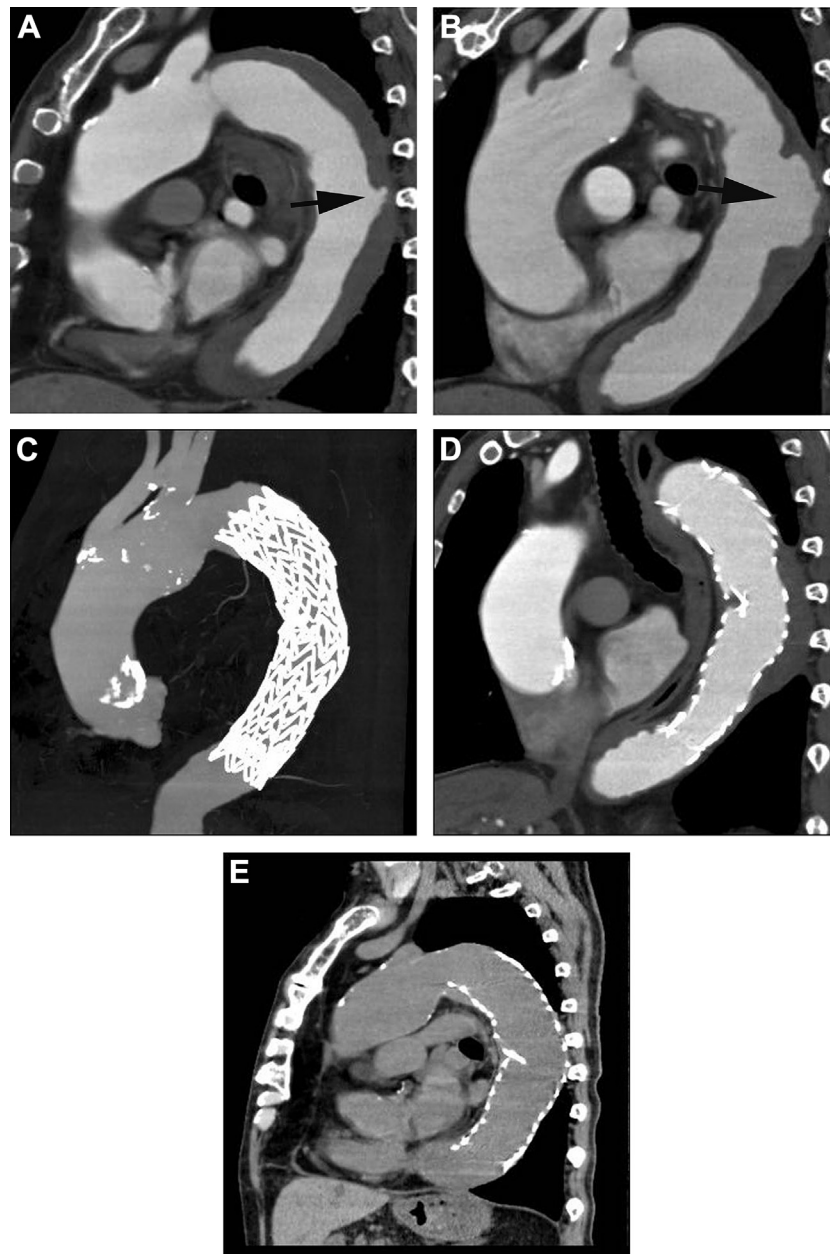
An 81-year-old woman with type B acute intramural hematoma (IMH) of the aorta. A, At onset, contrast-enhanced computed tomography (CT) images show the ulcer-like projection (ULP) in the descending aorta (*arrow*). B, A contrast-enhanced CT image 2 months after onset shows an enlarged ULP in the descending aorta (*arrow*). C and D, Contrast-enhanced CT images 2 weeks after endovascular treatment show that the ULP has disappeared. IMH has also decreased in size. E, A nonenhanced CT image 1 year after endovascular treatment shows that the IMH has disappeared.
